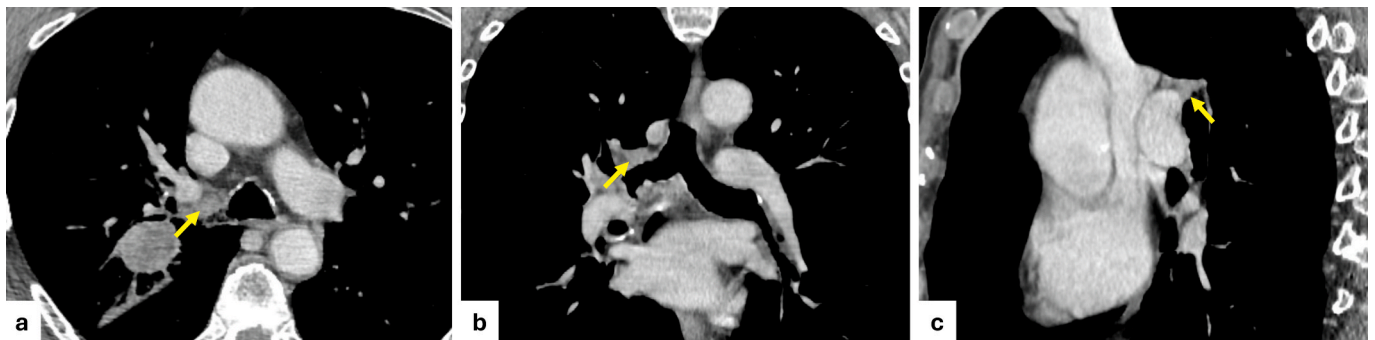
Example of agreement among readers in the assessment of a right hilar lymph node (station 10R), shown on axial (a), coronal (b), and sagittal (c) CT images (arrows). All four readers, regardless of expertise level, assigned a Node-RADS score of 4 or 5 (size: enlarged; configuration: ≥2). Cytological analysis confirmed malignancy.
